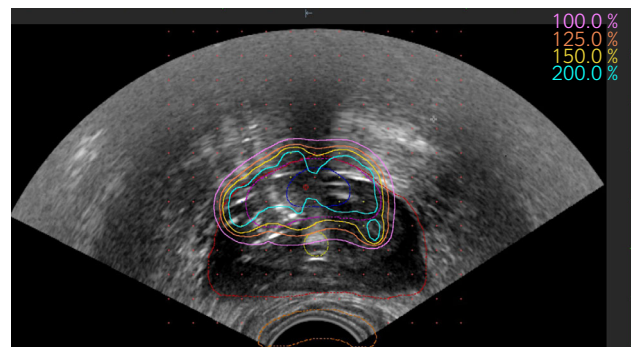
Post-implant dosimetry of salvage focal brachytherapy on transrectal ultrasound. The 100% isodose corresponds to 110 Gy. The entire prostate is contoured in red.
